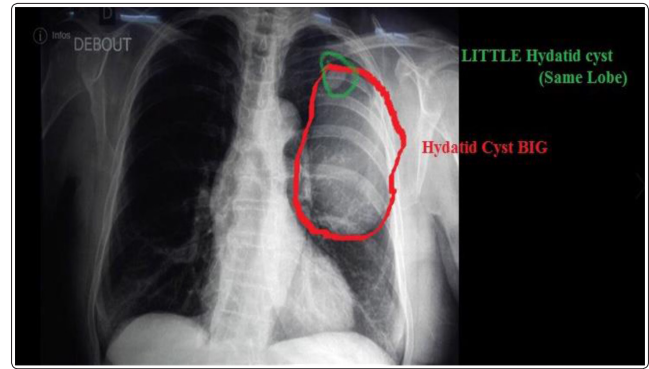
Chest X-Ray radiography showing two adjacent non-complicated hydatid cysts of the left lung. The upper cyst in green circle and the lower cyst in red circle
